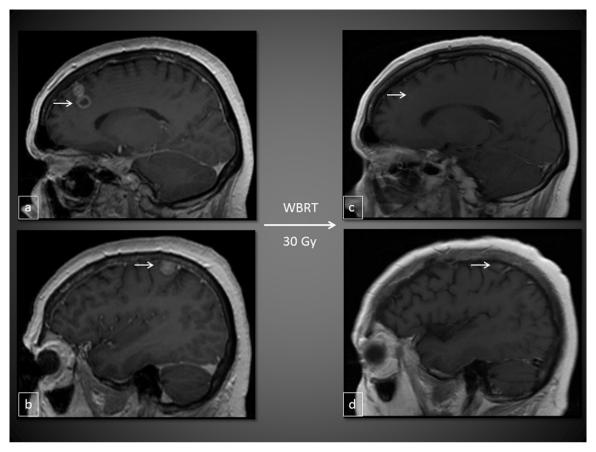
56 year old woman with ES-SCLC, metastatic to brain at the time of presentation. Sagittal T1-weighted contrast enhanced MRI of the brain shows (A) two enhancing left frontal lobe lesions and (B) a single left parietal metastasis. Following whole brain radiation with a total of 30 Gy in 10 fractions, only a faint blush is seen in the (C) frontal lobe and (D) parietal lobe, compatible with treated disease.
